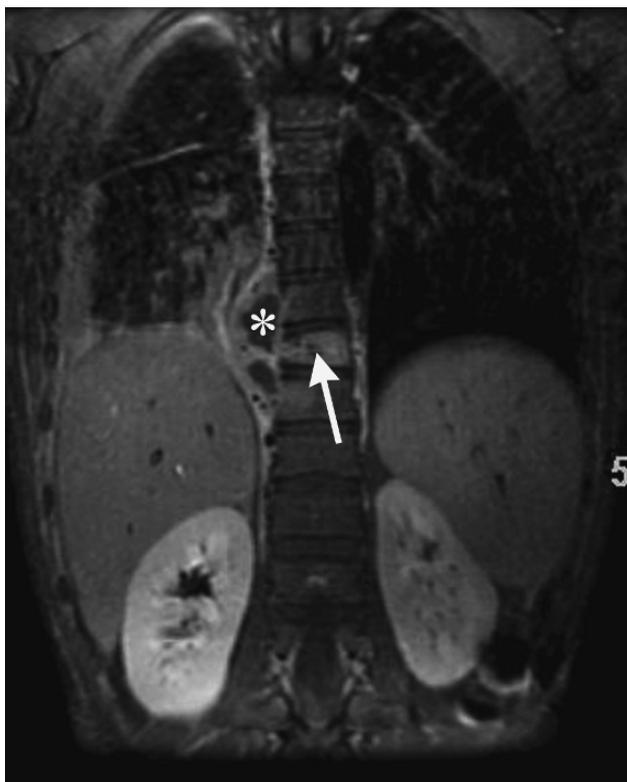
Coronal image from an MRI shows osteomyelitis of a thoracic vertebral body (arrow), and an adjacent paraspinal abscess (*), drained with ultrasound guidance.
